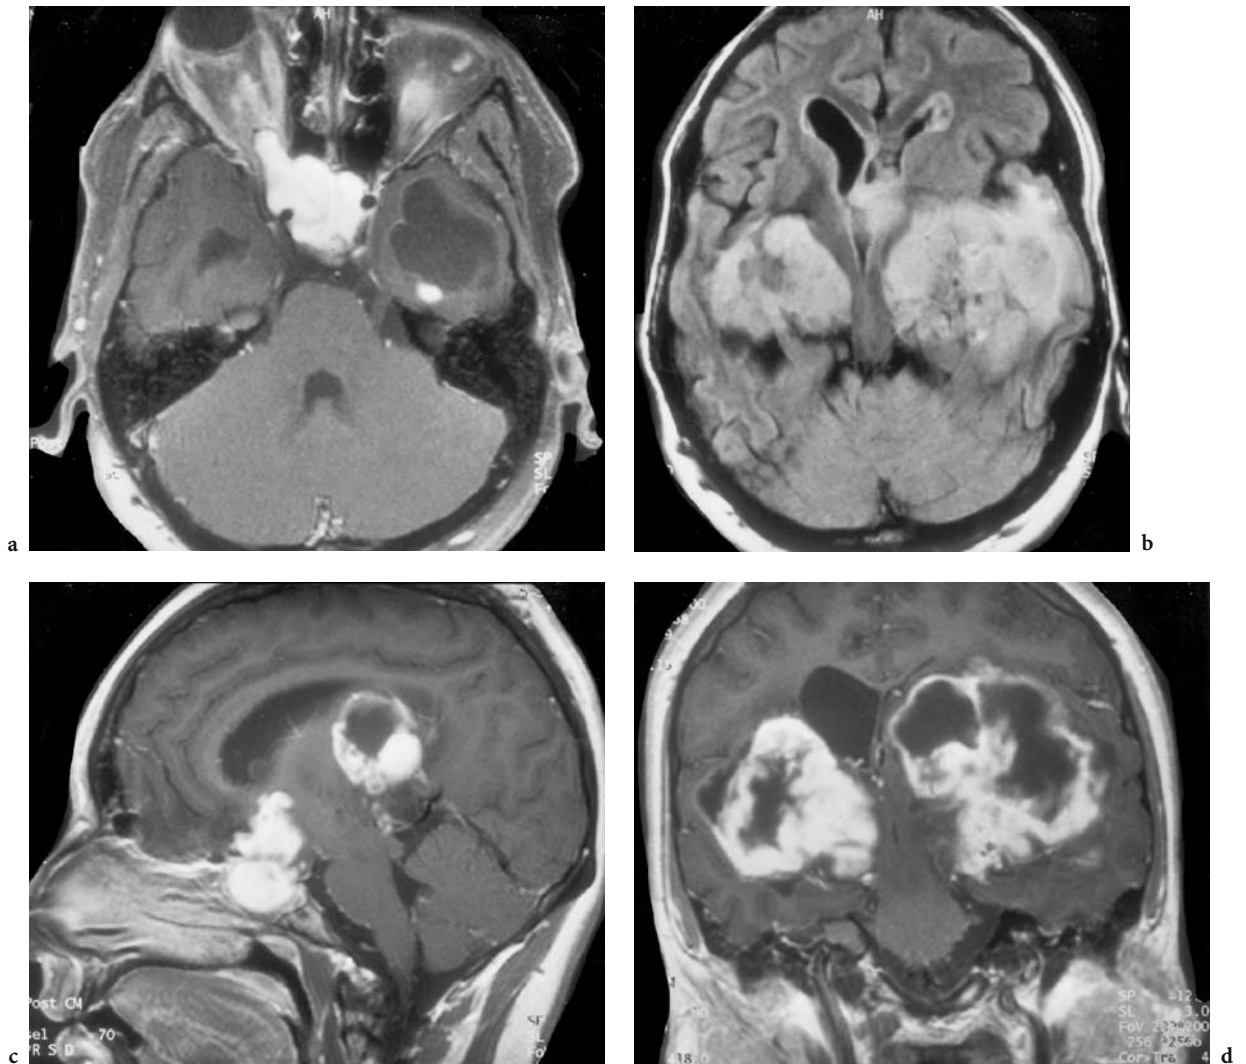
A 17 year old girl with complete blindness (and deafness) since childhood and a known neurofibromatosis. Diagnosis: astrocytoma WHO II. MRI: a Axial, T1-weighted, contrast-enhanced view at the level of the chiasm, showing the solid tumor in the entire suprasellar cistern, growing into the right optic nerve and canal with intraorbital expansion. Note a cystic tumor with a small, solid, contrast-enhancing tumor knot in the left temporal lobe. b Axial proton-weighted view, demonstrating the hypothalamic and bilateral thalamic infiltration, apparently arising from both optic tracts. c Sagittal, T1-weighted, contrast-enhanced view, in which not only the expansion into the sella with compression of the pituitary gland and hypothalamic infiltration is apparent, but another tumor part in the pulvinar of the thalamus is seen. d Coronal, T1-weighted, contrast-enhanced view showing the huge bilateral tumor expansion
